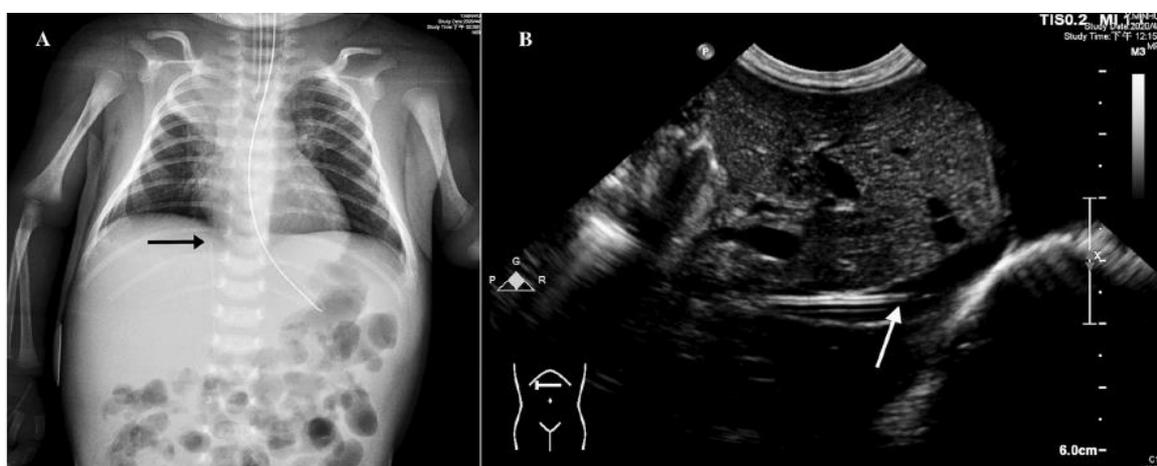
The tip location of PCVC in (A) black arrow CXR & (B) white arrow Ultrasonography of the same patient.
